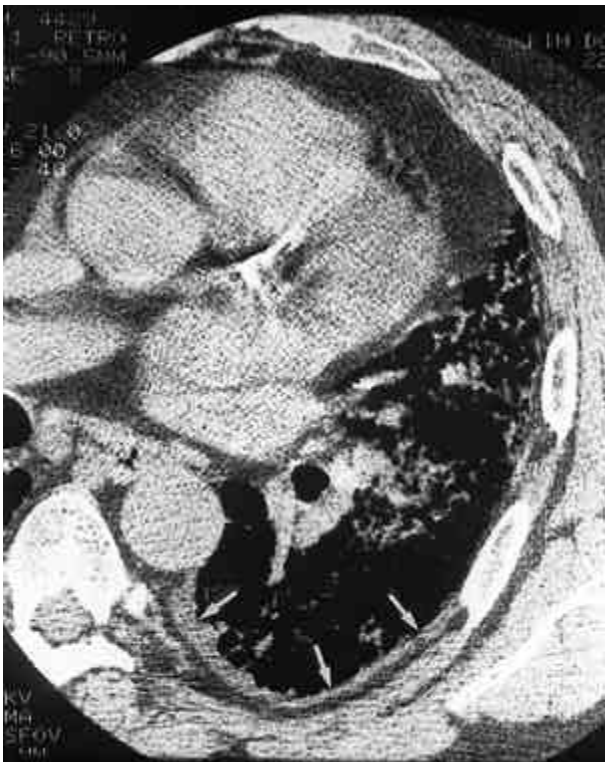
High-resolution CT of 57-year-old man with idiopathic pulmonary fibrosis shows thickening of the pleura more than 3 mm (arrows).
